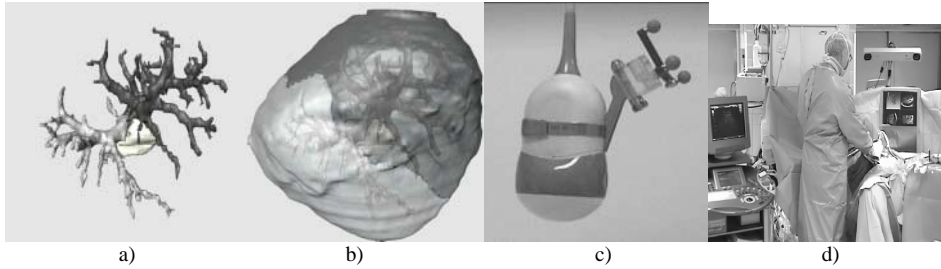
(a) Portal veins divided into to be resected (light grey) and remaining vessels (dark grey) resulting from tumor location (white). (b) Resulting vascular territories of liver parenchyma. (c) Position sensor fixed to 3D ultrasound probe. (d) Navigation system in the OR consisting of ultrasound device, Polaris camera, computer and monitor.
